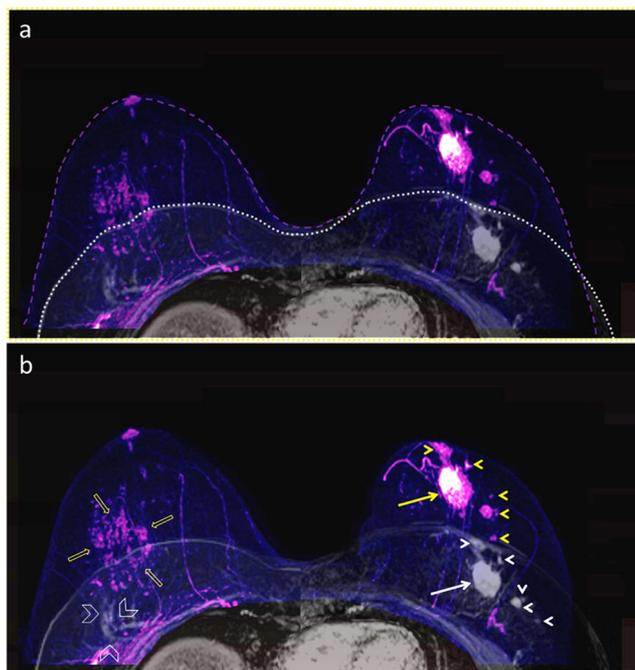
Patient no. 3 with multifocal invasive papillary carcinoma in the left breast and carcinoma in situ in the right breast as an incidental MRI finding. Fusion images of bilateral maximum intensity projection prone and supine MRI images. Tumours are shown pink colour-coded in the prone position and light grey in the supine position. a Shows the contours of the merged breasts, the purple dashed line indicates the contours in prone MRI and the white dotted line in supine MRI. b The main position of the tumour in the left breast (arrow) remained constant relative to the nipple. Minor changes are depicted in the other multifocal tumour positions (arrowheads). However, in the right breast the 6-cm non-mass lesion in the prone position (open arrows) shrunk antero-posteriorly to a 2-cm area in the supine position (open arrowheads)
